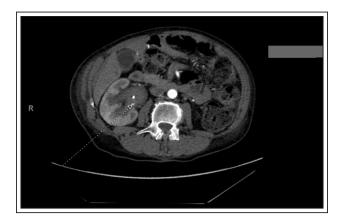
CT angiogram demonstated a small area of extravasation in the right kidney. The location was similar to where the pseudoaneurysm had been seen endoscopically.
